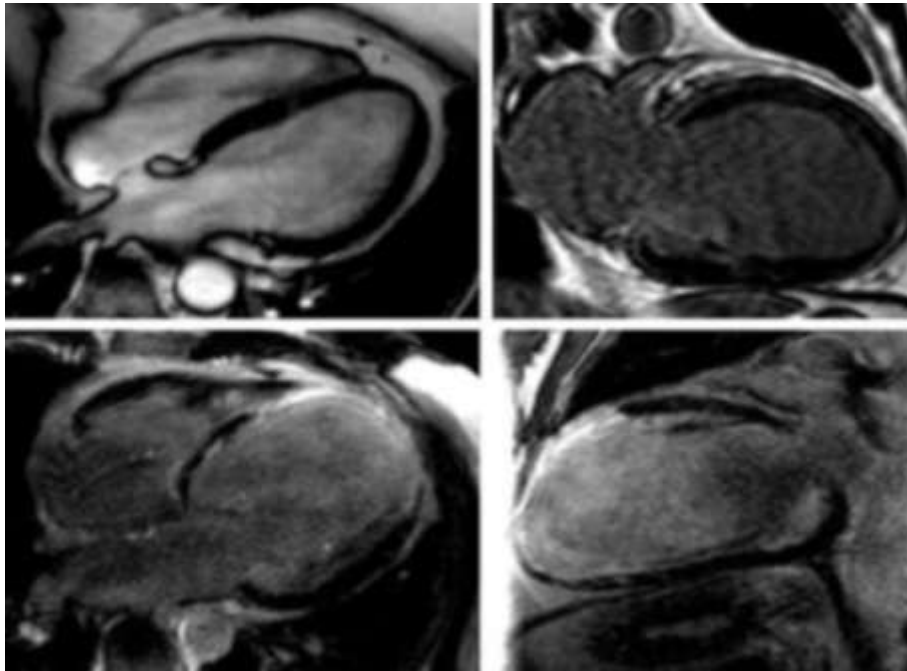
Cardiac MRI showing dilatation and dysfunction of left ventricle.
